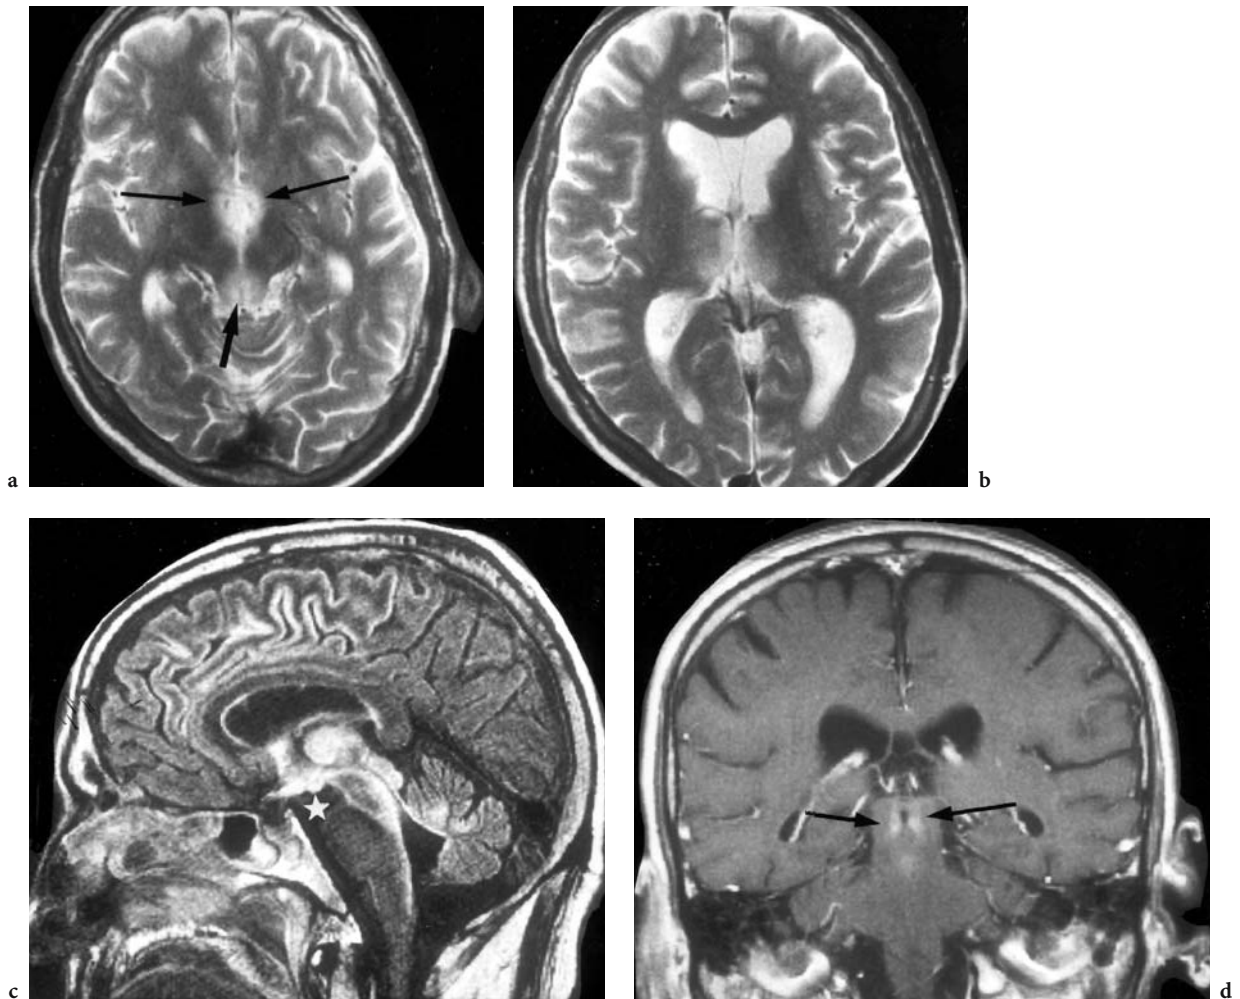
A 58-year-old man, known alcoholic, who needed resuscitation when he was found in an unconscious condition of unknown duration. MRI: a Axial T2-weighted view at the level of the anterior commissure, demonstrating a periaqueductal (*arrow*) and diencephalic (*thin arrows*) signal enhancement. b Axial T2-weighted view 10 mm above with hyperintensity of the periventricular (to the third ventricle) thalami. c Midsagittal T2-weighted (FLAIR) view which shows the entire lesion reaching from the hypothalamus, mammillary bodies (*white star*), thalamus, whole tegmentum, and floor and roof of the fourth ventricle. Note the cortical enhancement of the frontal brain parenchyma, residuals of hypoxemia (laminar necrosis). d Coronal, T1-weighted, contrast-enhanced view, where the periaqueductal BBB disruption (*thin arrows*) is apparent. (With permission of Dr. Lorenz, Radiology Department of St. Vincenz Hospital, Mainz)
